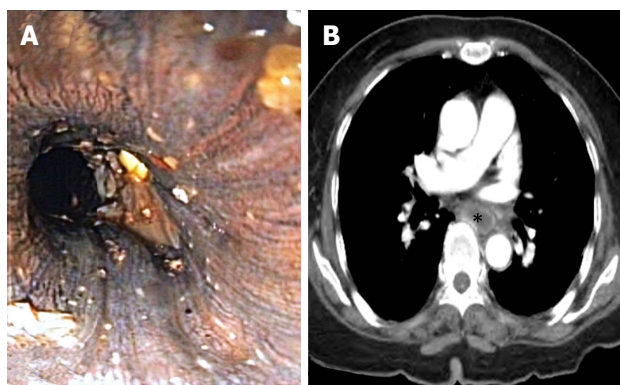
Endoscopic view suggested extensive mucosal necrosis of the esophagus -Grade IIIb modified Zargar's endoscopic classification, but CT scan revealed mucosal enhancement of the esophagus indicating tissue viability. A: Endoscopic view; B: Computerized tomography scan. Notably, esophageal lumen is marked with asterisk.
